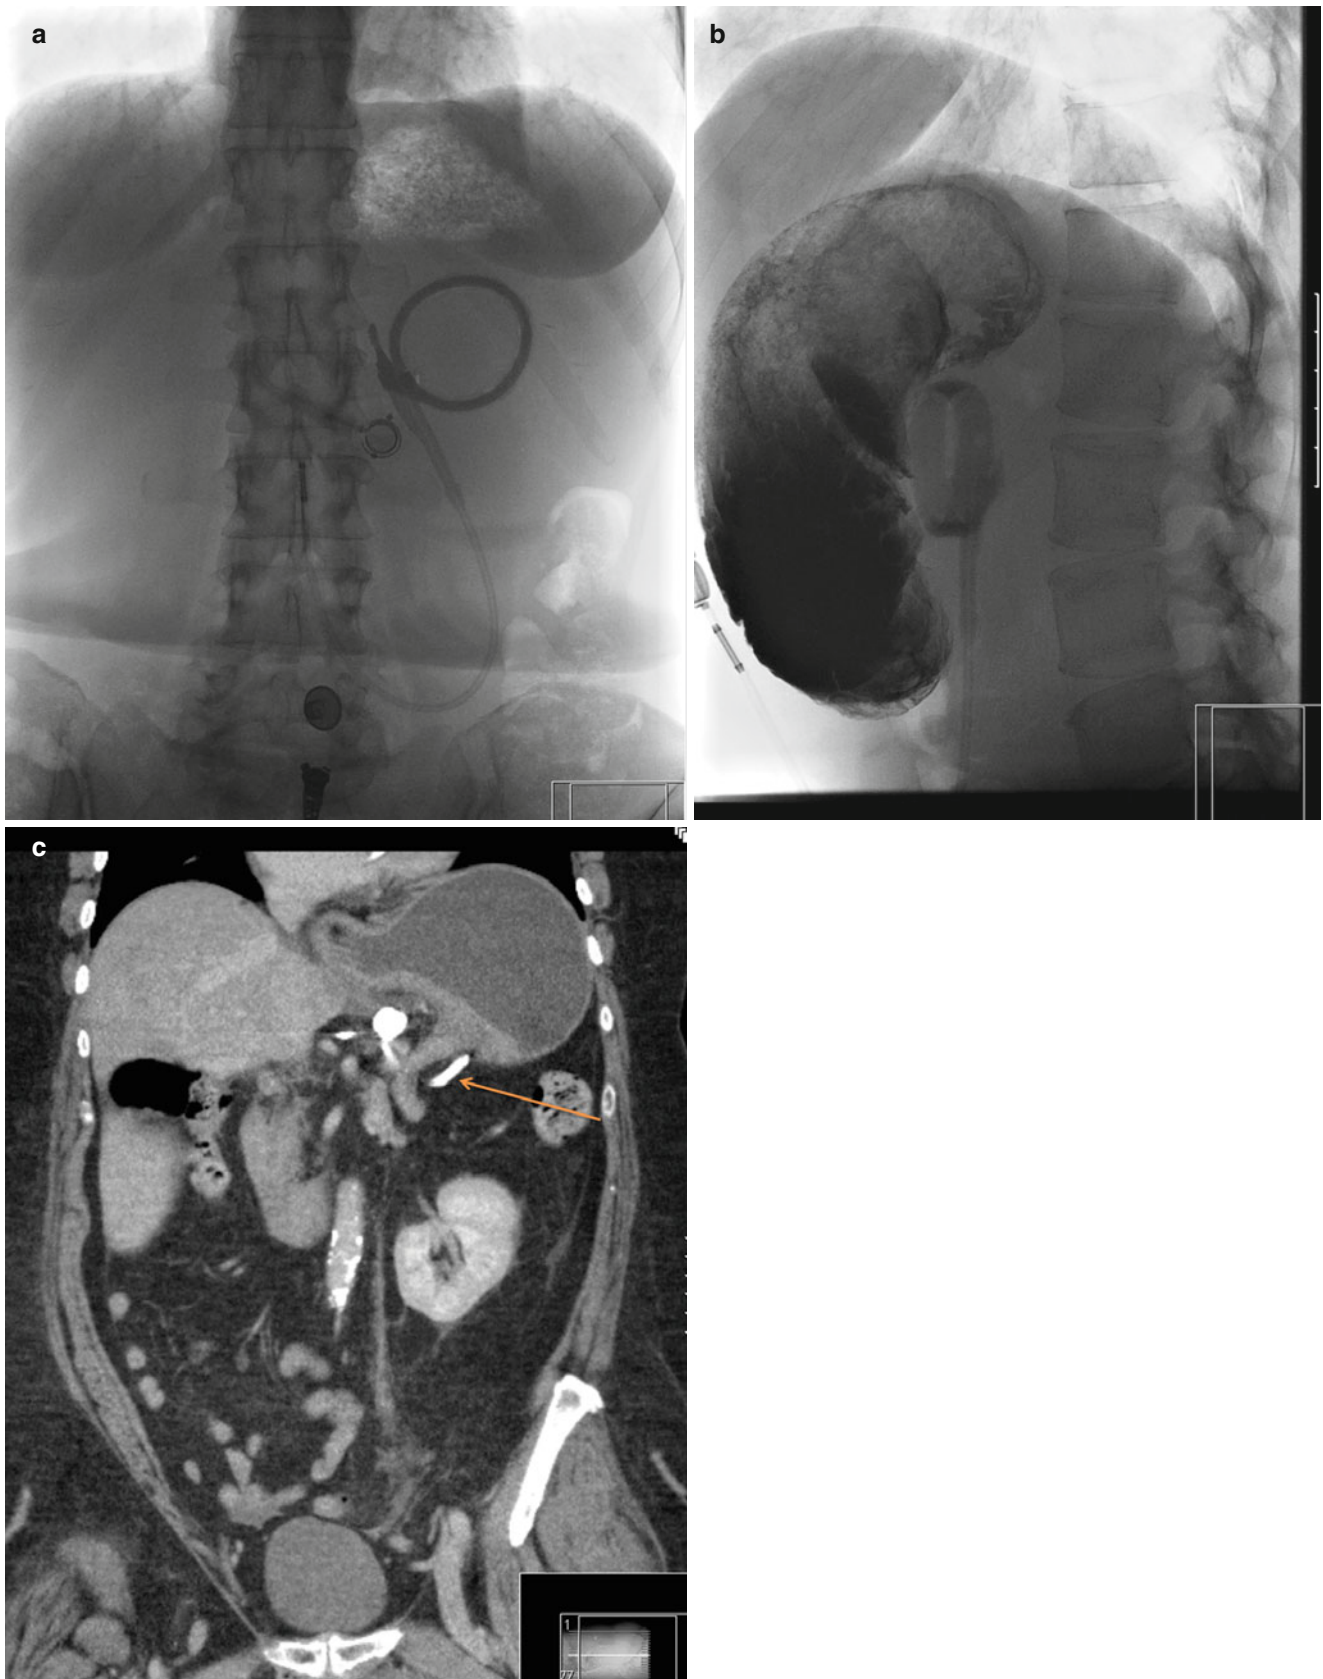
Slipped gastric band. (a) An abnormal orientation of the band. (b) Slipped band causes moderate obstruction. (c) Different patient, Computed tomography showing slipped gastric band (*arrow*) with proximal dilatation
